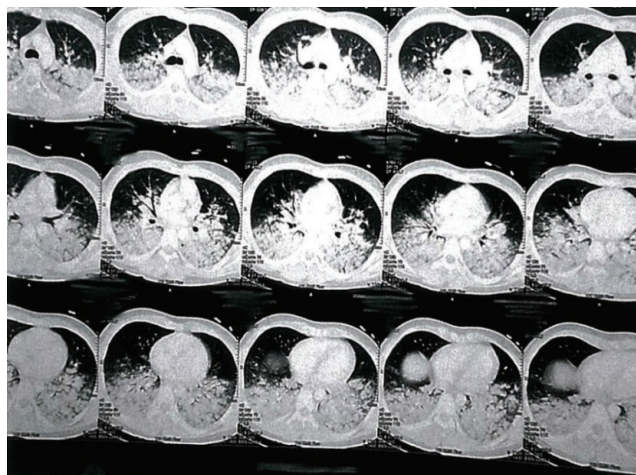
CT of the chest, lung window. Bilateral diffuse opacities are seen in the supine view of the patient. Source: *Axial CT thorax with contrast, showing ARDS with severe worsening.*
